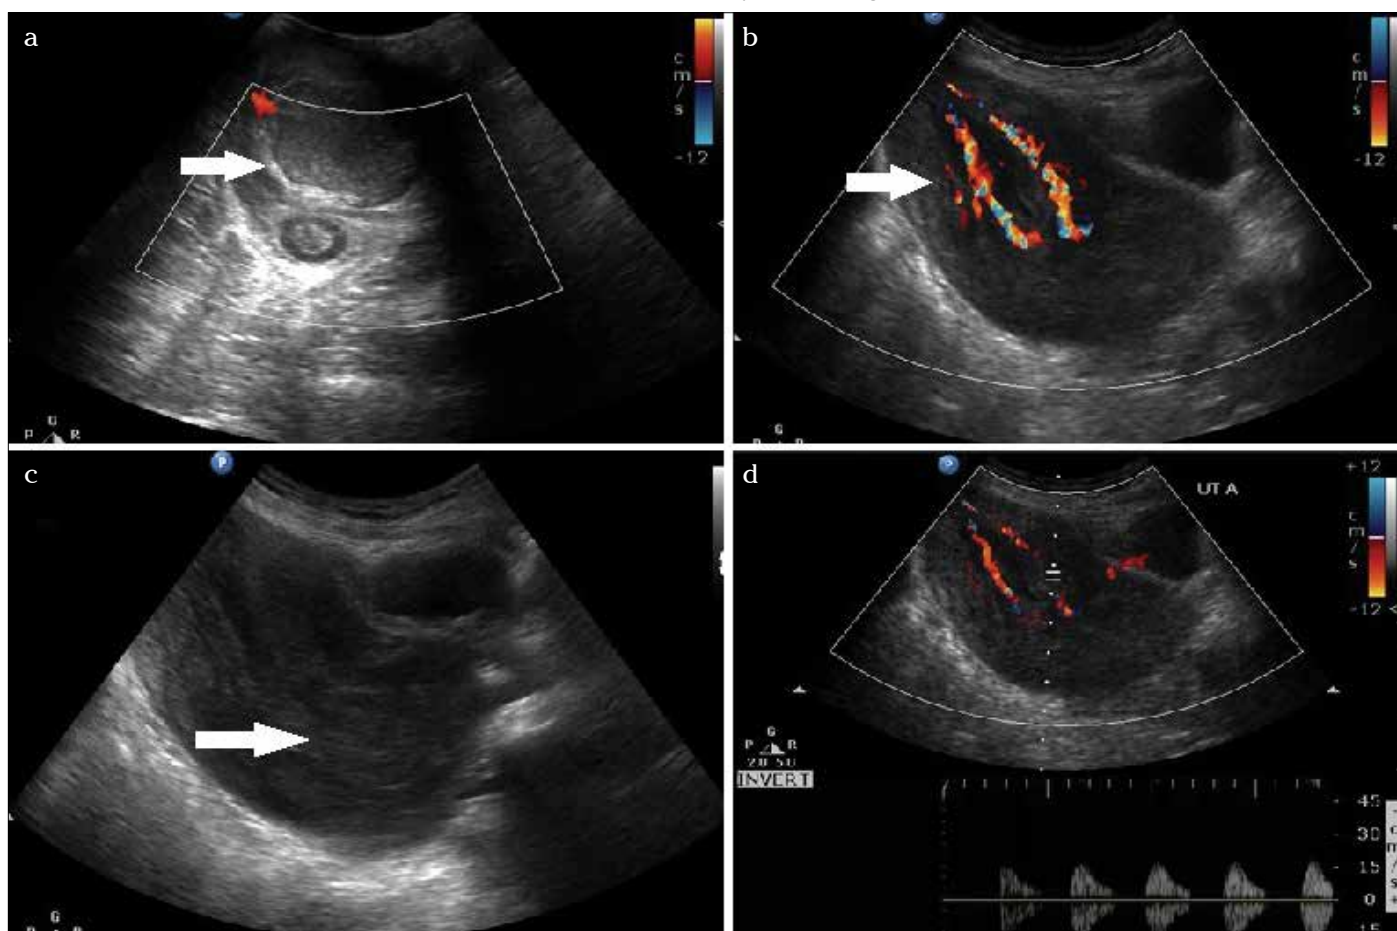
a-d. Pelvic ultrasound image (coronal view) shows target sign (solid arrow), i.e., hyperechoic fundus with mass surrounded by hypoechoic layer of fluid inside the vagina (a), pelvic color mode ultrasound image (sagittal view) shows inverted fundus with pulled pedicles (solid arrow) (b), pelvic ultrasound image (sagittal view) shows pseudo stripe sign (solid arrow), i.e., outer serosal surfaces coming into contact mimicking normal endometrial stripe (c), pelvic spectral Doppler mode ultrasound image (sagittal view) shows a normal uterine artery waveform in pulled uterine vascular pedicle (d)
